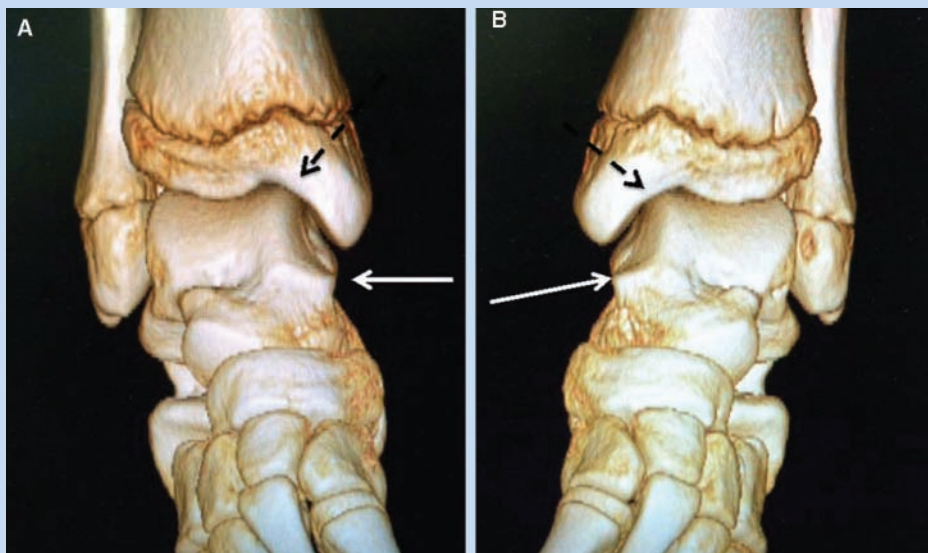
A, 3-dimensional reconstructive CT scan of medial impingement osteophytes in a male teenage soccer player. The prominent spur on the leading edge of the medial talar facet (solid arrow) and the “kissing” lesion spur on the tibial side (broken arrow) covers the corner of the medial ankle joint. B, left ankle computed tomography of the patient in A with similar findings. Inferiorly, the talar spurs extend on both sides. At surgery, they must be removed in their entirety.
